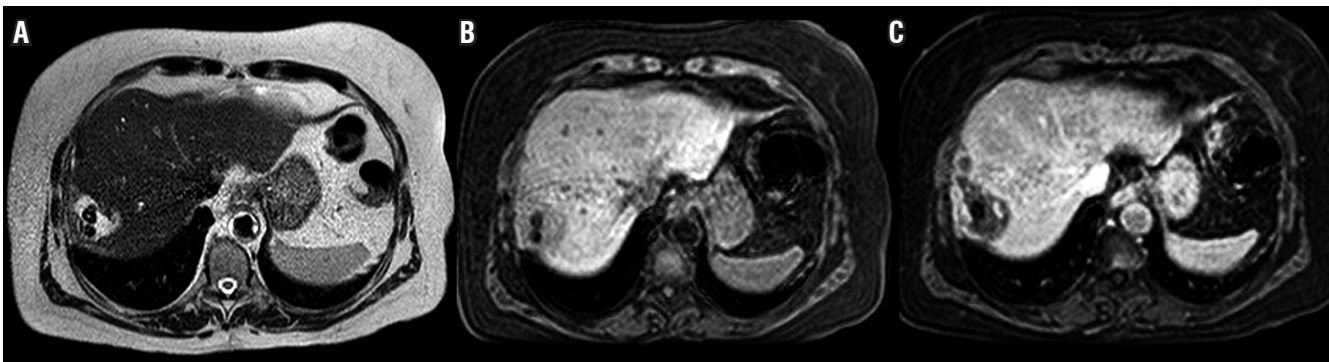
A-B. T1 and T2 W MRI. Perihepatic fluid collection with two hypo intense defects within it, corresponding to dropped gallstones. C. Post contrast MRI showing peripheral enhancement of the collection without enhancement of the stones.
